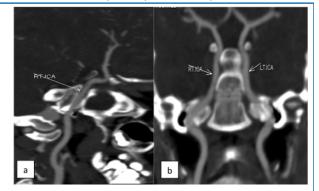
Reformatted sagittal(a) and coronal (b) images of follow up CT angiography showing resolution of previously noted focal stenosis of cavernous segment of right ICA.
